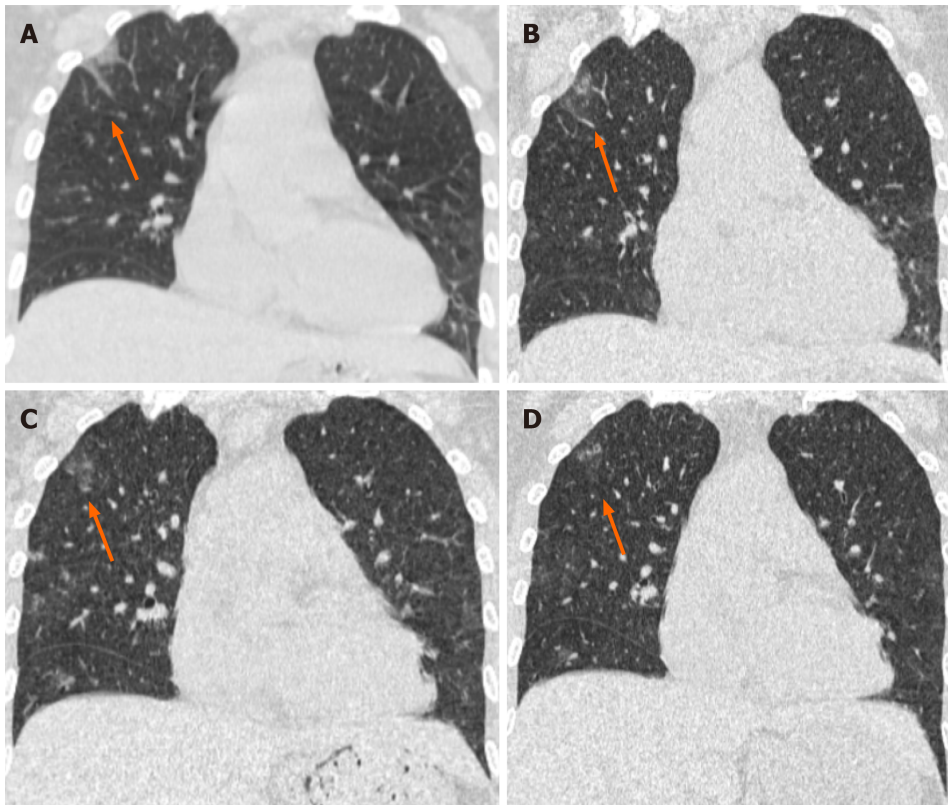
Unenhanced computed tomography images in a 49-year-old woman (coronal imaging). Computed tomography radiographs show a patchy and striate shadow of slightly high density in the upper right lung (arrows), as the treatment progressed, this asymmetrical lesion was gradually absorbed. A: Day 7 (2020.1.26) after the onset of symptoms; B: Day 12 (2020.1.31) after the onset of symptoms; C: Day 16 (2020.2.4) after the onset of symptoms; D: Day 21 (2020.2.9) after the onset of symptoms.
